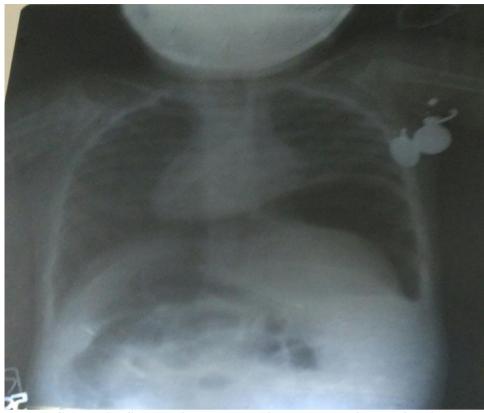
X-RAY film showing pneumoperitoneum due to ileal perforation
